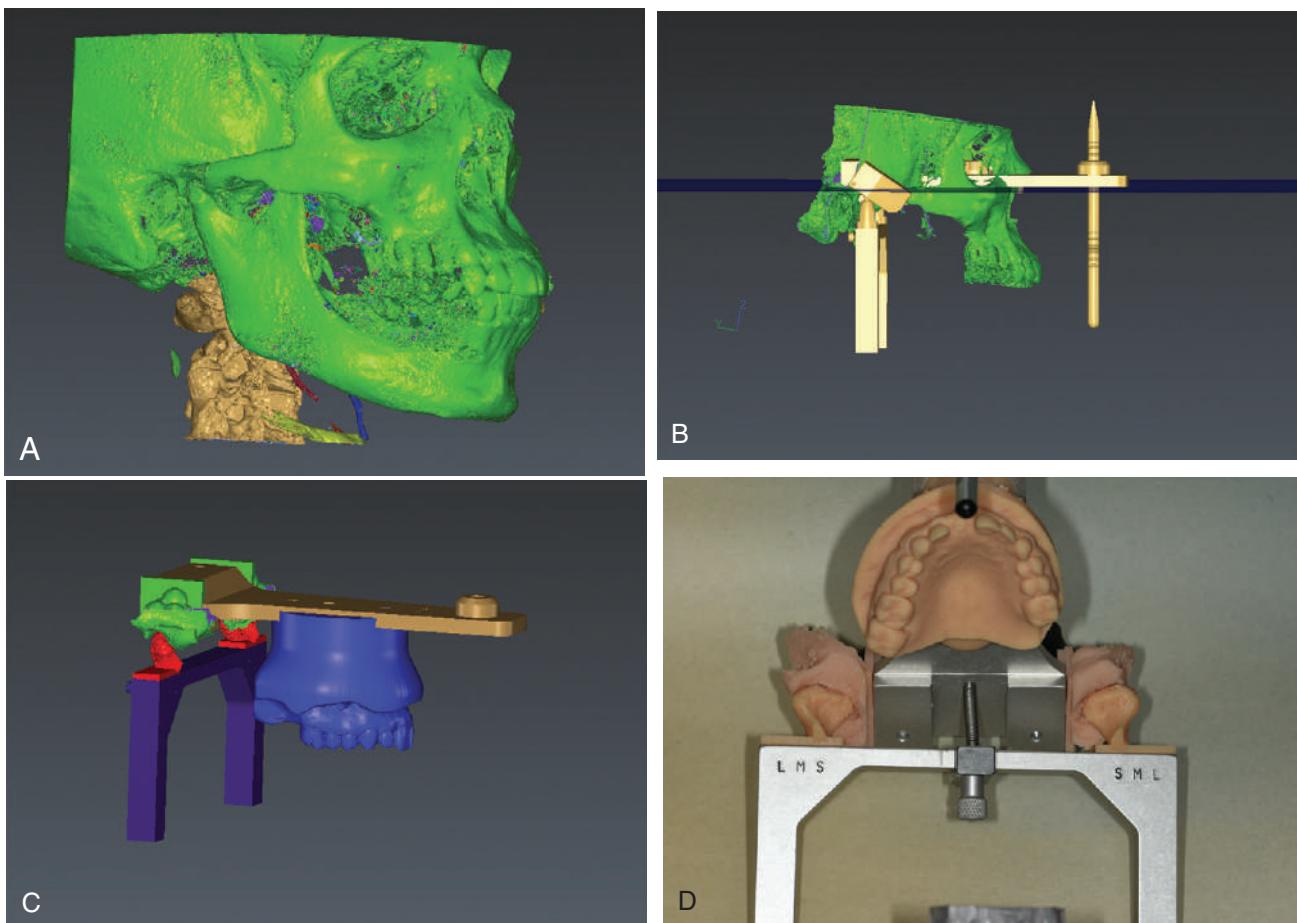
The Patient Specific Anatomical Articulator. (A) Patient cone-beam computed tomography data are converted to STL file. (B) The articulator upper member aligned to the Frankfurt horizontal plane. (C) Patient anatomic landmarks exactly related to the articulator as they are in reality. (D) True anatomic relationship of condyles, fossae, and maxilla maintained in exact relationship as the patient, eliminating the need for a facebow transfer.
